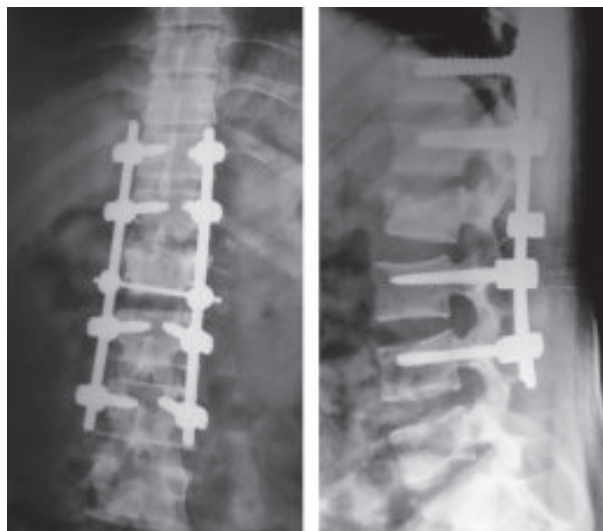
A 25-years-old man with AO type B and incomplete neurologic deficit. (A) Antero-posterior postoperative radiograph (B) Postoperative lateral radiograph after posterior surgery.
